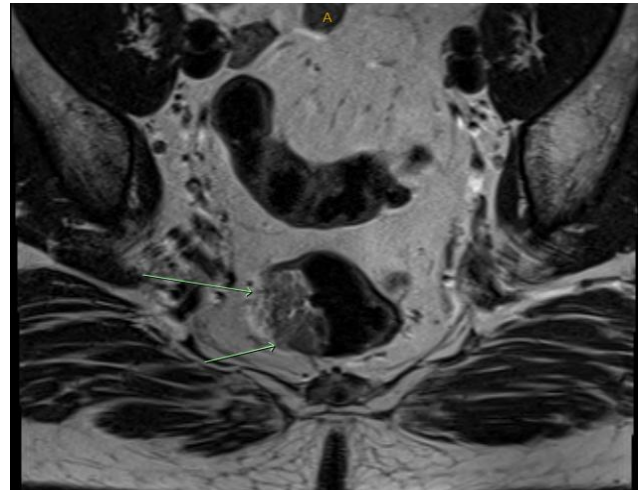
Axial T2-weighted pelvic MRI demonstrating rectal lesion without extramural invasion (case 1).
